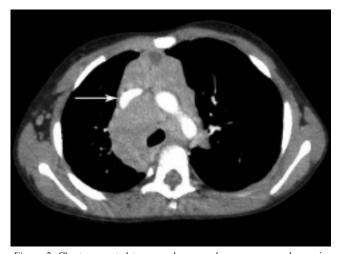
Chest computed tomography scan shows a narrowed superior vena cava, displaced by the large adenopathy.
